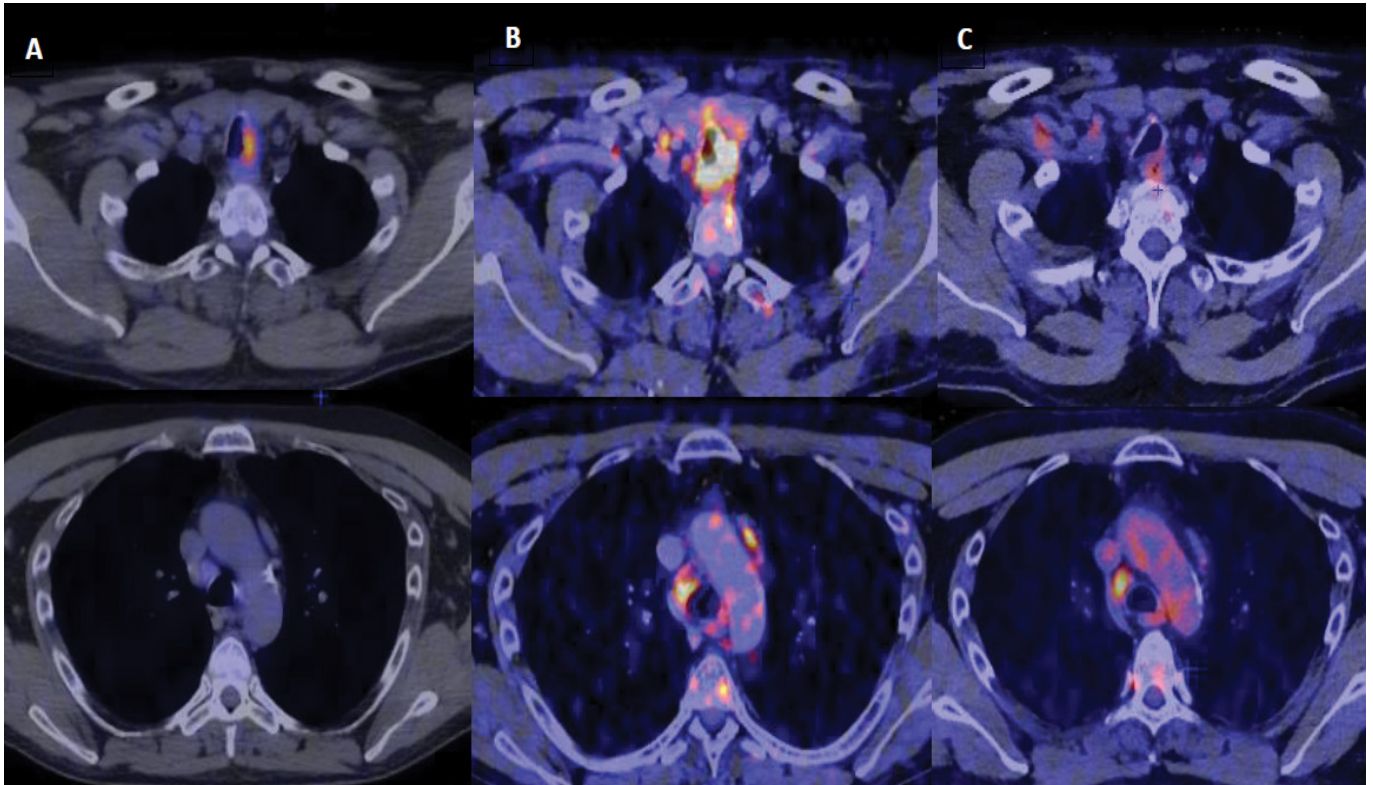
Evolution of PET CT scans before radiotherapy treatment.
